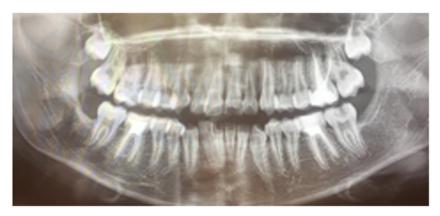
The healing of all hard tissues in the area of the cystic lesions was observed after 1 year radiographic control.
